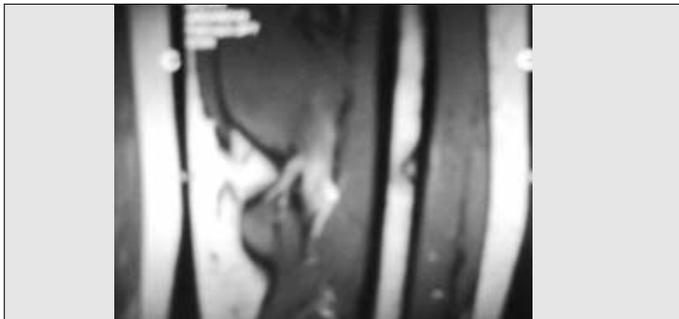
Microfracture line in left femur MRI.
